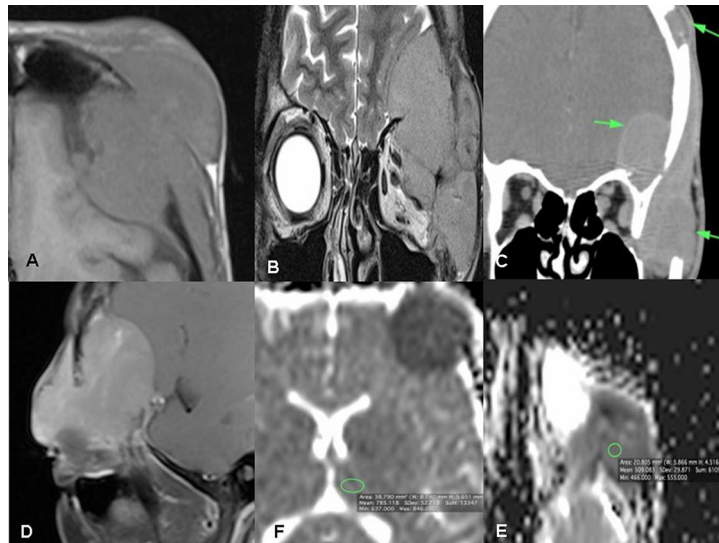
A 26-year-old female rapidly growing swelling in the lateral aspect of the left orbit, associated with proptosis, headache and dull aching left orbital pain and cervical lymphadenopathy. Axial T1 image A shows hypointense infiltrative mass involving the left lacrimal gland, the left extraconal fat, the lateral bony wall, the left side of skull base, as well as the roof of the left orbit, and has a related left frontal epidural component. Coronal T2 image B shows slightly hyperintense mass displacing the extraconal muscles and the left optic nerve infero-medially. Non-contrast complementary CT study soft tissue window C reveals bone destruction of the left lateral orbital wall, left orbital roof, and lesser wing of sphenoid bone (green arrows). Sagittal T1 post-contrast image D shows mild enhancement of the left orbital mass. Evident diffusion restriction on DWI (b_{1000})/ADC (E, F). The ADC value of $0.52 \times 10^{-3} \text{mm}^2/\text{sec}$. Pathologically proved left orbital extraconal infiltrative lymphoma
